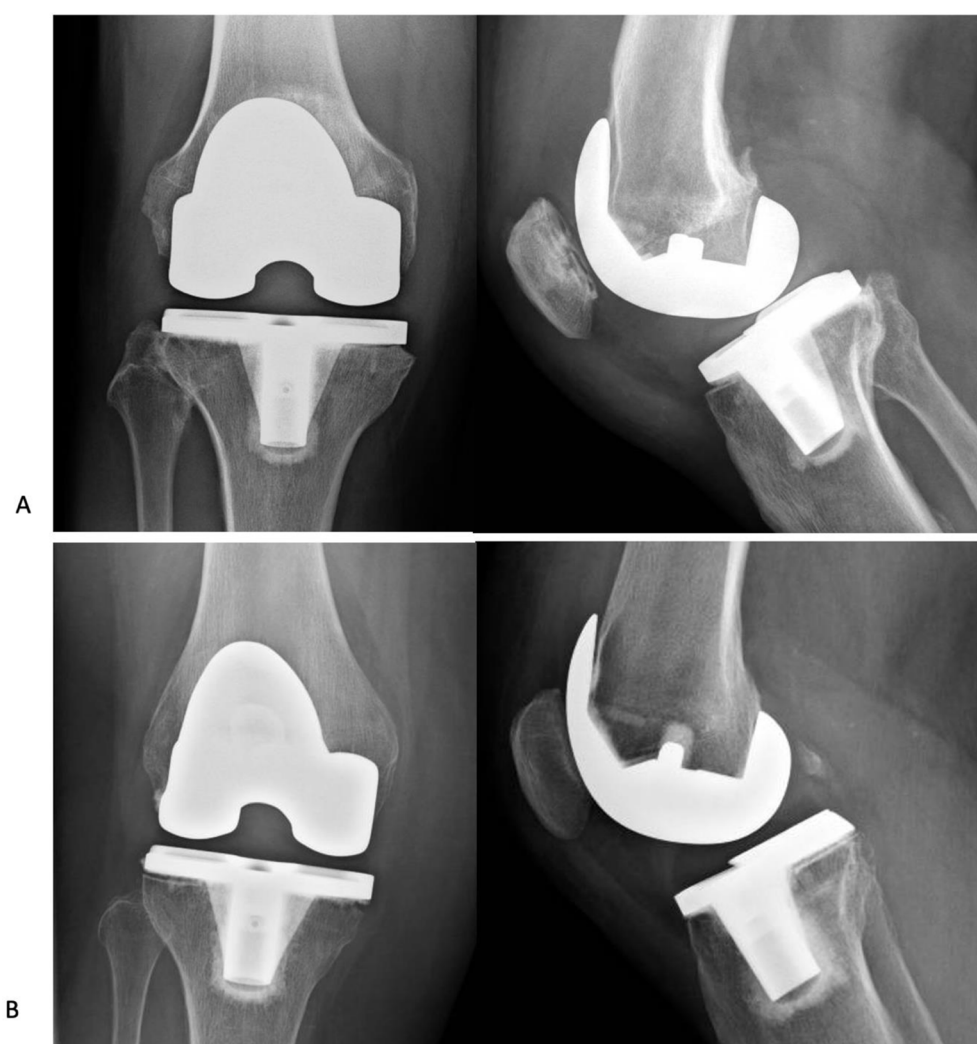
Post-operative X-rays of Persona implant without stubby stem *a* Persona implant with Isolated RLL *b* Persona implant with Combined RLLs
